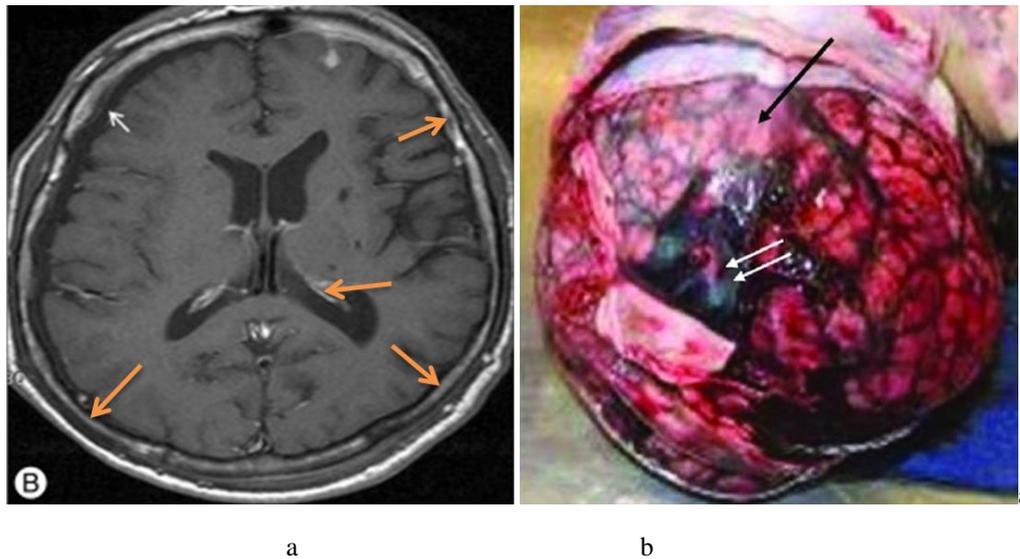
a: Neomembranes on CT imaging (at orange arrows and all around) with acute blood (white and lighter color) highlighting their structure within the underlying chronic subdural hematoma. b: neomembrane at autopsy as thin film at large black arrow and acute blood for recent rebleed at double white arrows.
